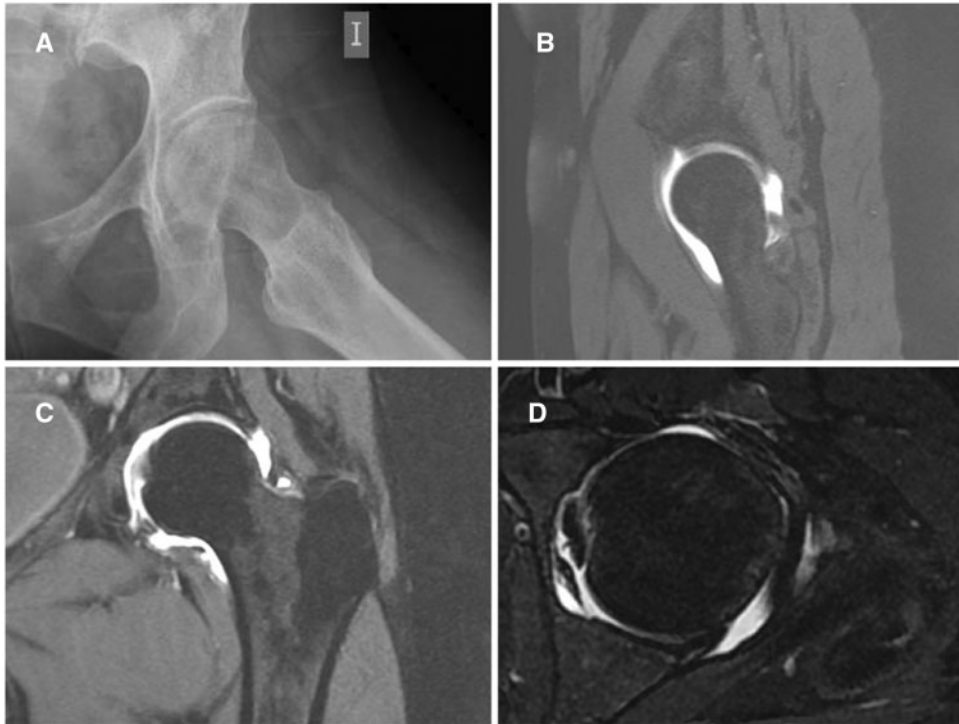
(A) Antero-posterior hip radiography showing markedly coxa-anteversa with double line sign due to calcification of the posterior labrum. (B–D) MRI in short inversion time inversion recovery (STIR) signal, showing a sagittal (B), coronal (C) and axial (D) views of the left hip, where signs of chondrolabral delamination, associated with narrowing of the posterior joint space can be observed.
